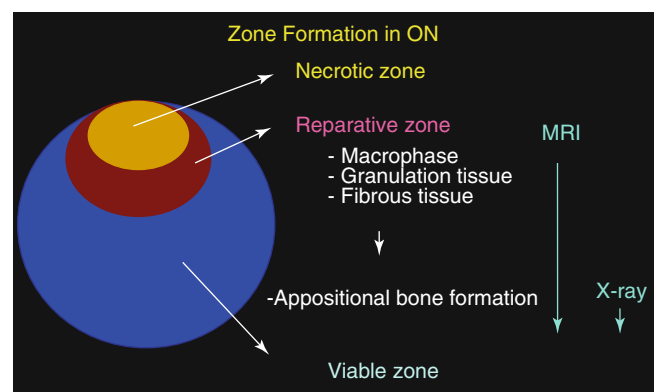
Zone formation in ON. A wedge-shaped necrotic area is seen in a subchondral area, which is surrounded by the reparative tissue. This reparative tissue continues to the normal viable bone and bone marrow tissue. In the early phase of ON, the reparative tissue generally consists of infiltration macrophage, granulation tissue, and fibrous tissue, which can only be recognized on MRI. Thereafter, bony repair such as an appositional bone formation or creeping substitution occurs, when radiograph can detect these bony changes as a sclerotic change
